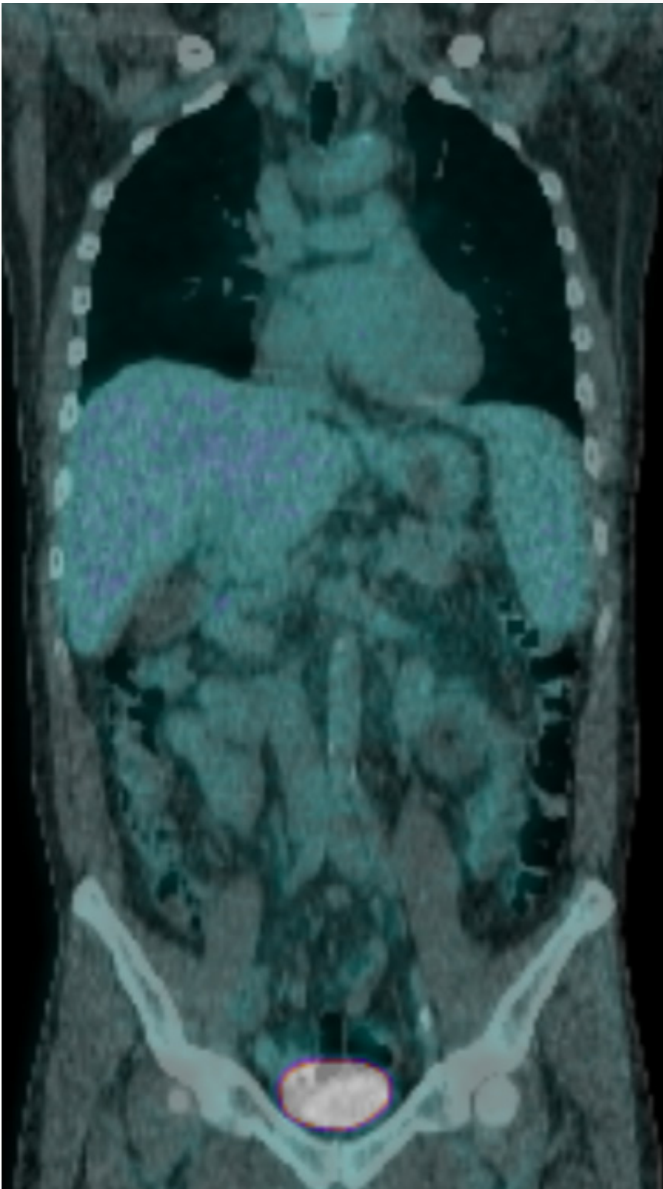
PET did not reveal any site with significant FDG uptake.
